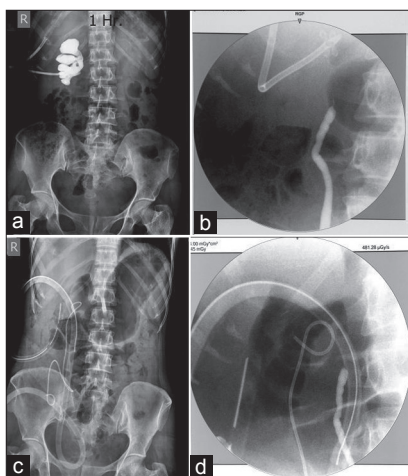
(a) Nephrostogram showing complete cut-off at the pelvi-ureteric junction with intrarenal pelvis. (b) Retrograde ureterogram showing cut-off at L2 vertebral level. (c) X-ray kidney, ureter and bladder region showing malpositioned caudal end of double J (DJ) stent. (d) Retrograde ureterogram showing DJ stent lateral to ureter
